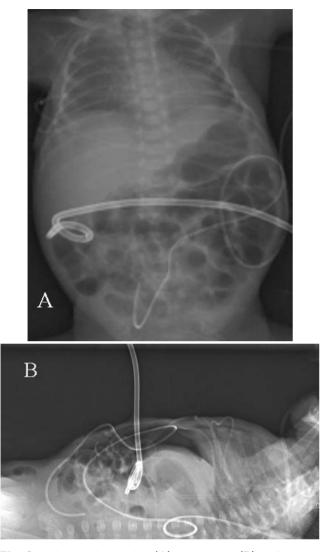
Plain anterioposterior (A) and lateral (B) radiographs of the abdomen revealed that the pigtail drainage catheter was inserted into the peritoneal cavity and located below the liver showing free air under the non-dependent portion (age of 8 day).
